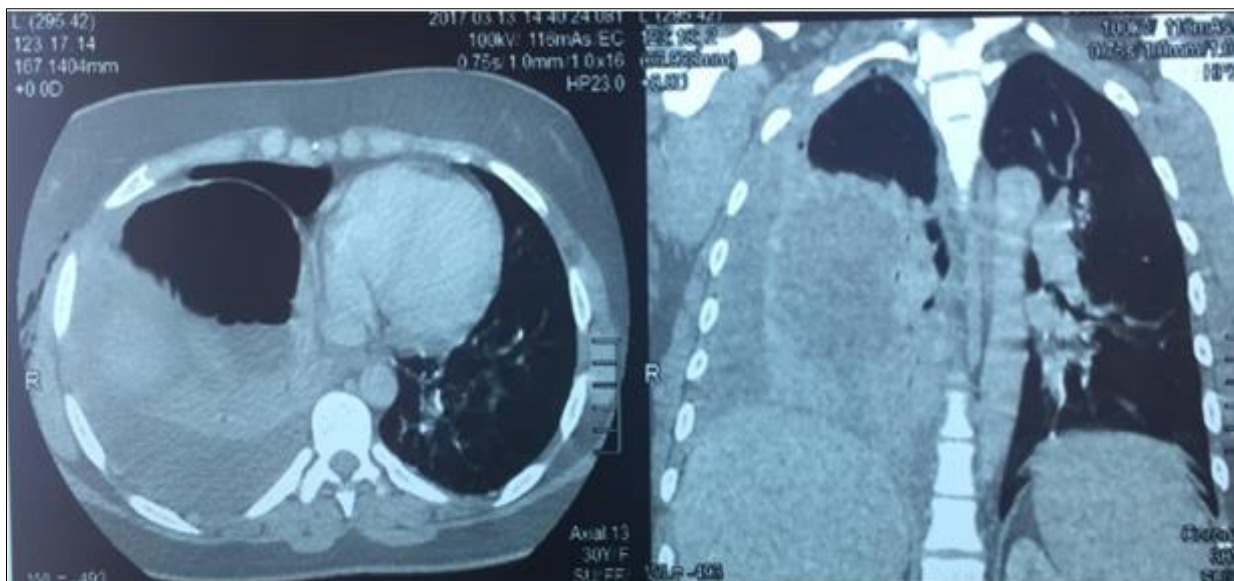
CT scan appearance of a ruptured hydatid cyst in the pleura with pleural effusion
